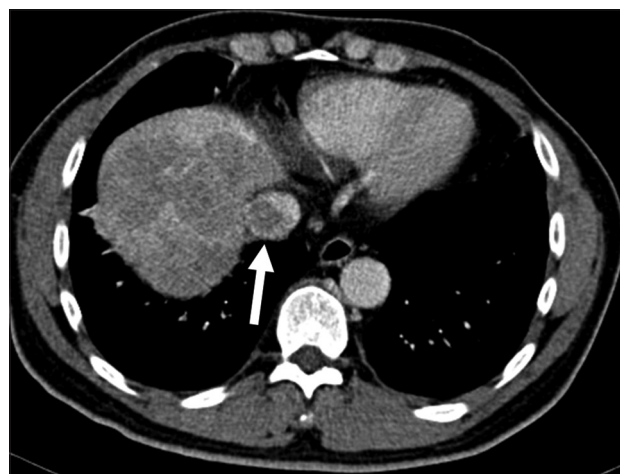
Portal venous phase CT showing a filling defect within the intrahepatic IVC from a tumor thrombus extending from the right lobe tumor (white arrow)
